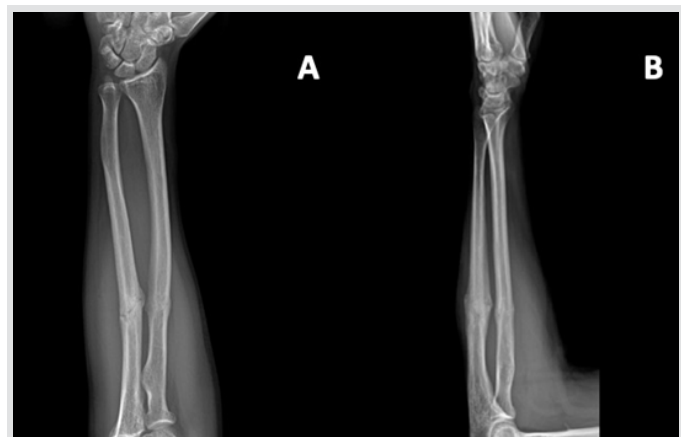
AP (a) and lateral (b) X-rays demonstrate the same fractures with complete bony callus formation 3 months after injury.
